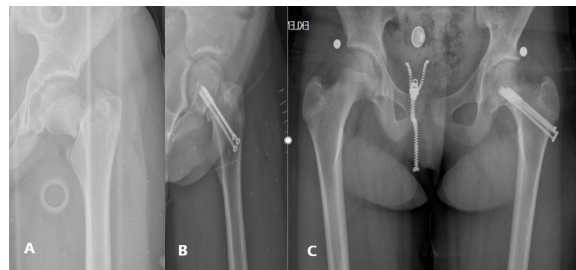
11 year-old female with Delbett type 3 displaced left hip fracture following fall from height A. Preoperative roentgenogram B. Postoperative roentgenogram showing good (<4mm displacement and <5 degree angulation) reduction and fixation C. 15 months after initial trauma showing moderate varus and early closure of the growth plate
